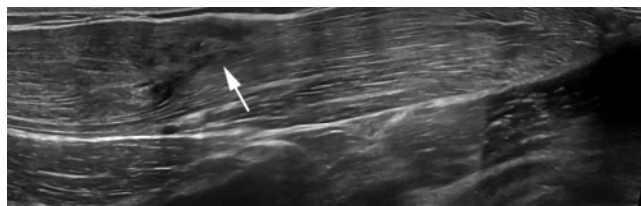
Ultrasound control with a 5-16 Mhz lineal probe in a longitudinal panoramic view at 1 month after treatment in which a correct disposition of the pectoralis major muscle fibers without evidence of fibrotic scarring or complications.
